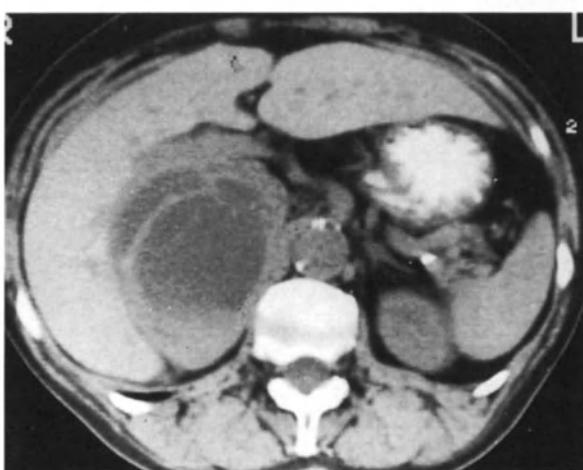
CT scan unenhanced. Large right pheochromocytoma with cystic areas. The mass is displacing liver.
